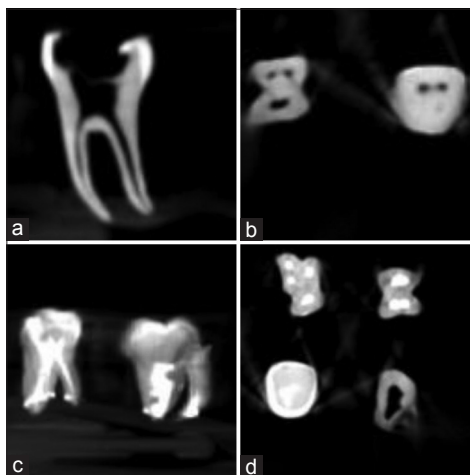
(a and b) Cone beam computed tomography. (c and d) Contrast media injected in the canal differentiates and highlights the complexity of the root canal system
